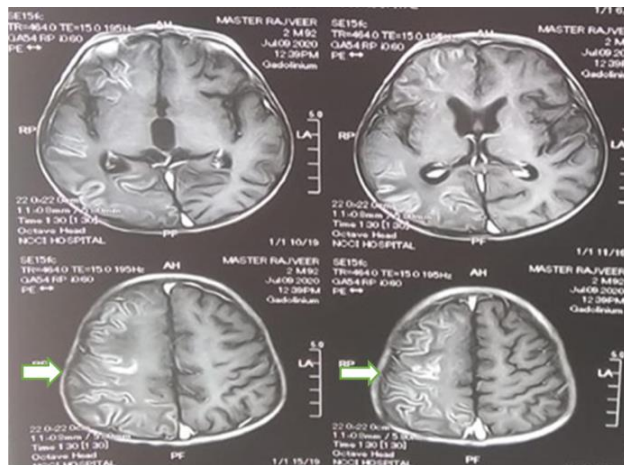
MRI brain axial images revealed cortical and subcortical large area of abnormal signal intensity seen in fronto-parietal and occipital cortex on the right side along with laminar necrosis
